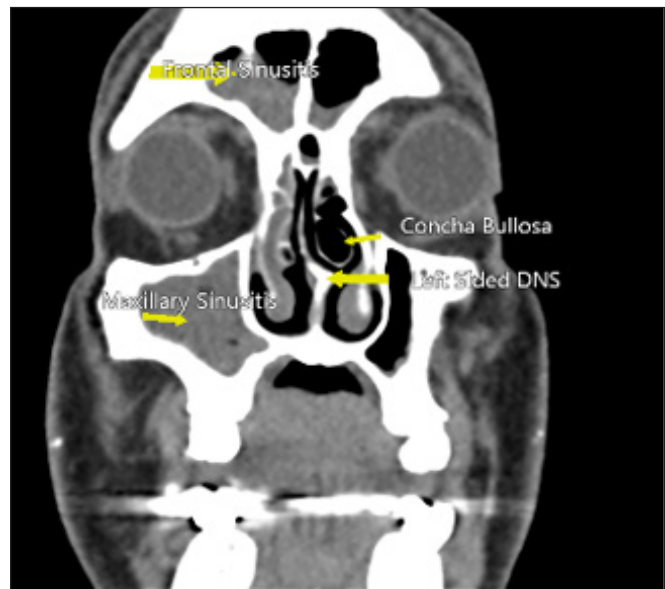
Coronal view CT of the paranasal sinuses shows the presence of normal anatomical variants, such as a left concha bullosa and a deviated nasal septum towards the left. The right maxillary sinus is completely opacified, and there is mild mucosal thickening in both frontal sinuses consistent with maxillary and frontal sinusitis.
